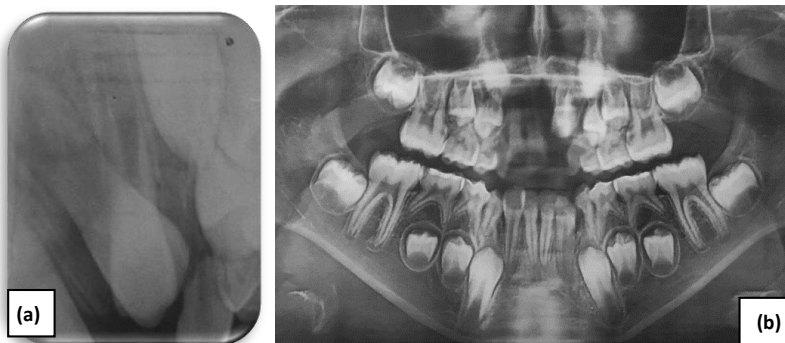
Radiological follow-up after 6 months showing bone reossification + disappearance of the lesion (a) retroalveolar radiography, (b) panoramic radiography.
